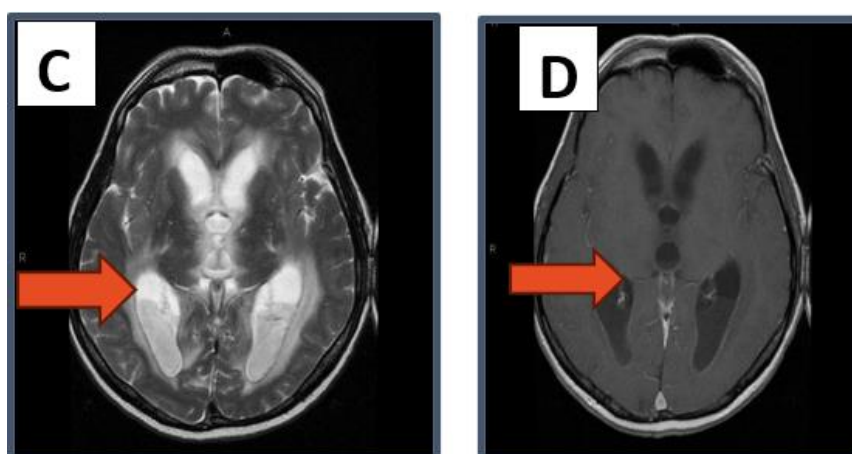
Figure C, D: magnetic resonance imaging (MRI)
